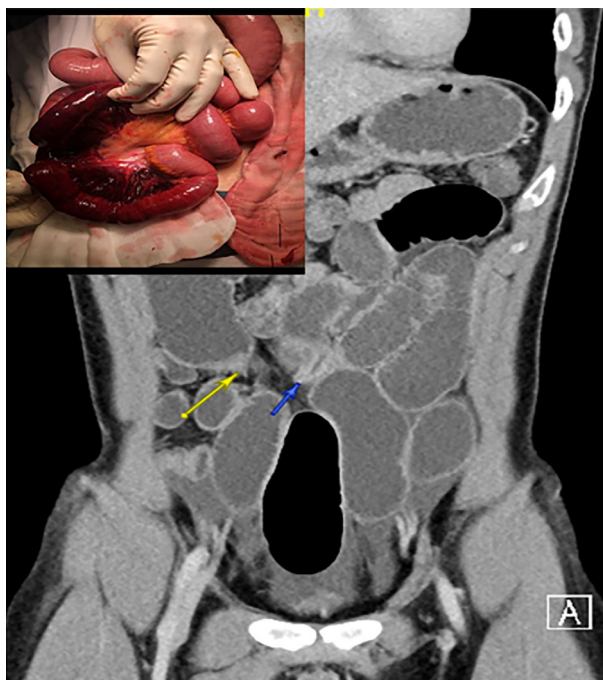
A patient with a history of surgery for intussusception as an infant and showing symptoms of small bowel obstruction. The computed tomography scan shows dilated distal jejunal loop with two transition points close to each other, suggestive of closed-loop small bowel obstruction. Top left inset: intraoperative photograph of bowel ischemia caused by small bowel obstruction secondary to acquired adhesions. Yellow and blue arrows point to the transition points of the closed-loop obstruction.
